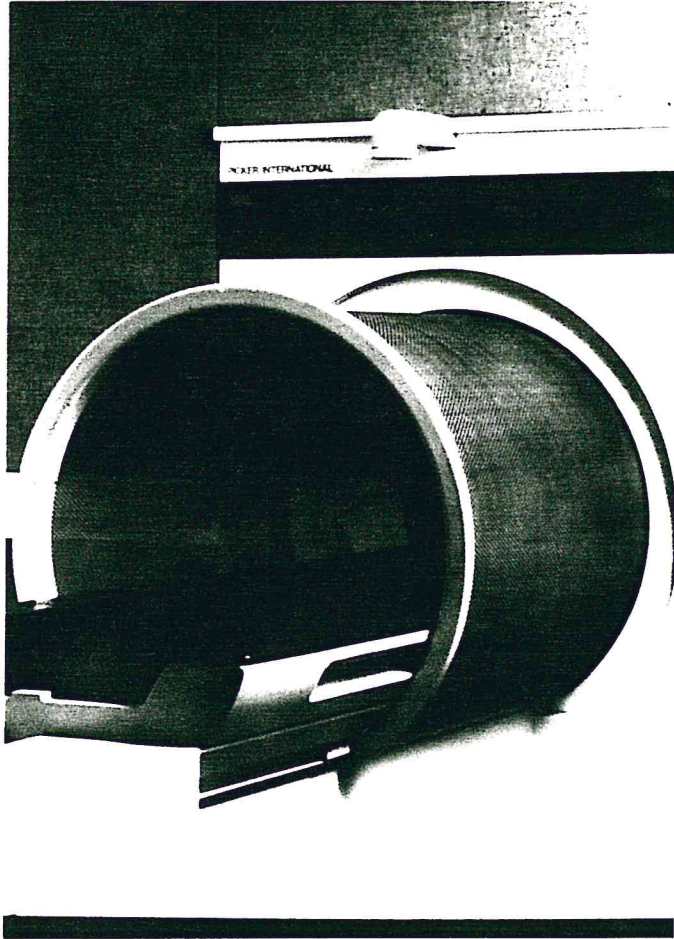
VISTA magnetic resonance imager.
